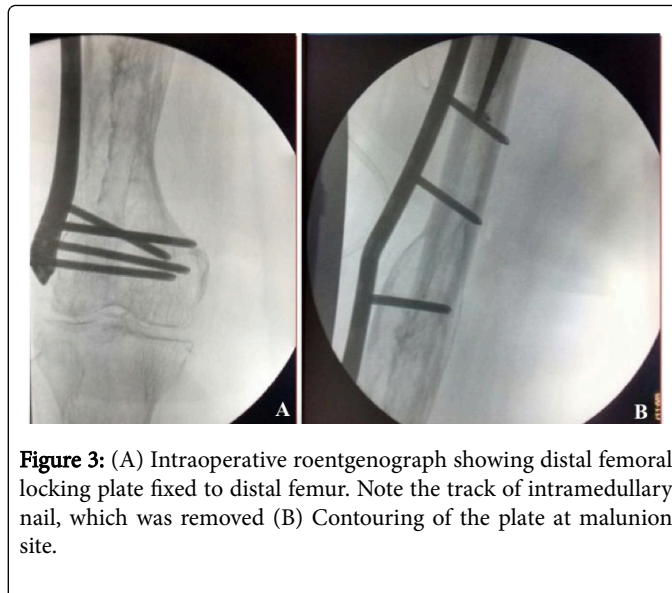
(A) Intraoperative roentgenograph showing distal femoral locking plate fixed to distal femur. Note the track of intramedullary nail, which was removed (B) Contouring of the plate at malunion site.
